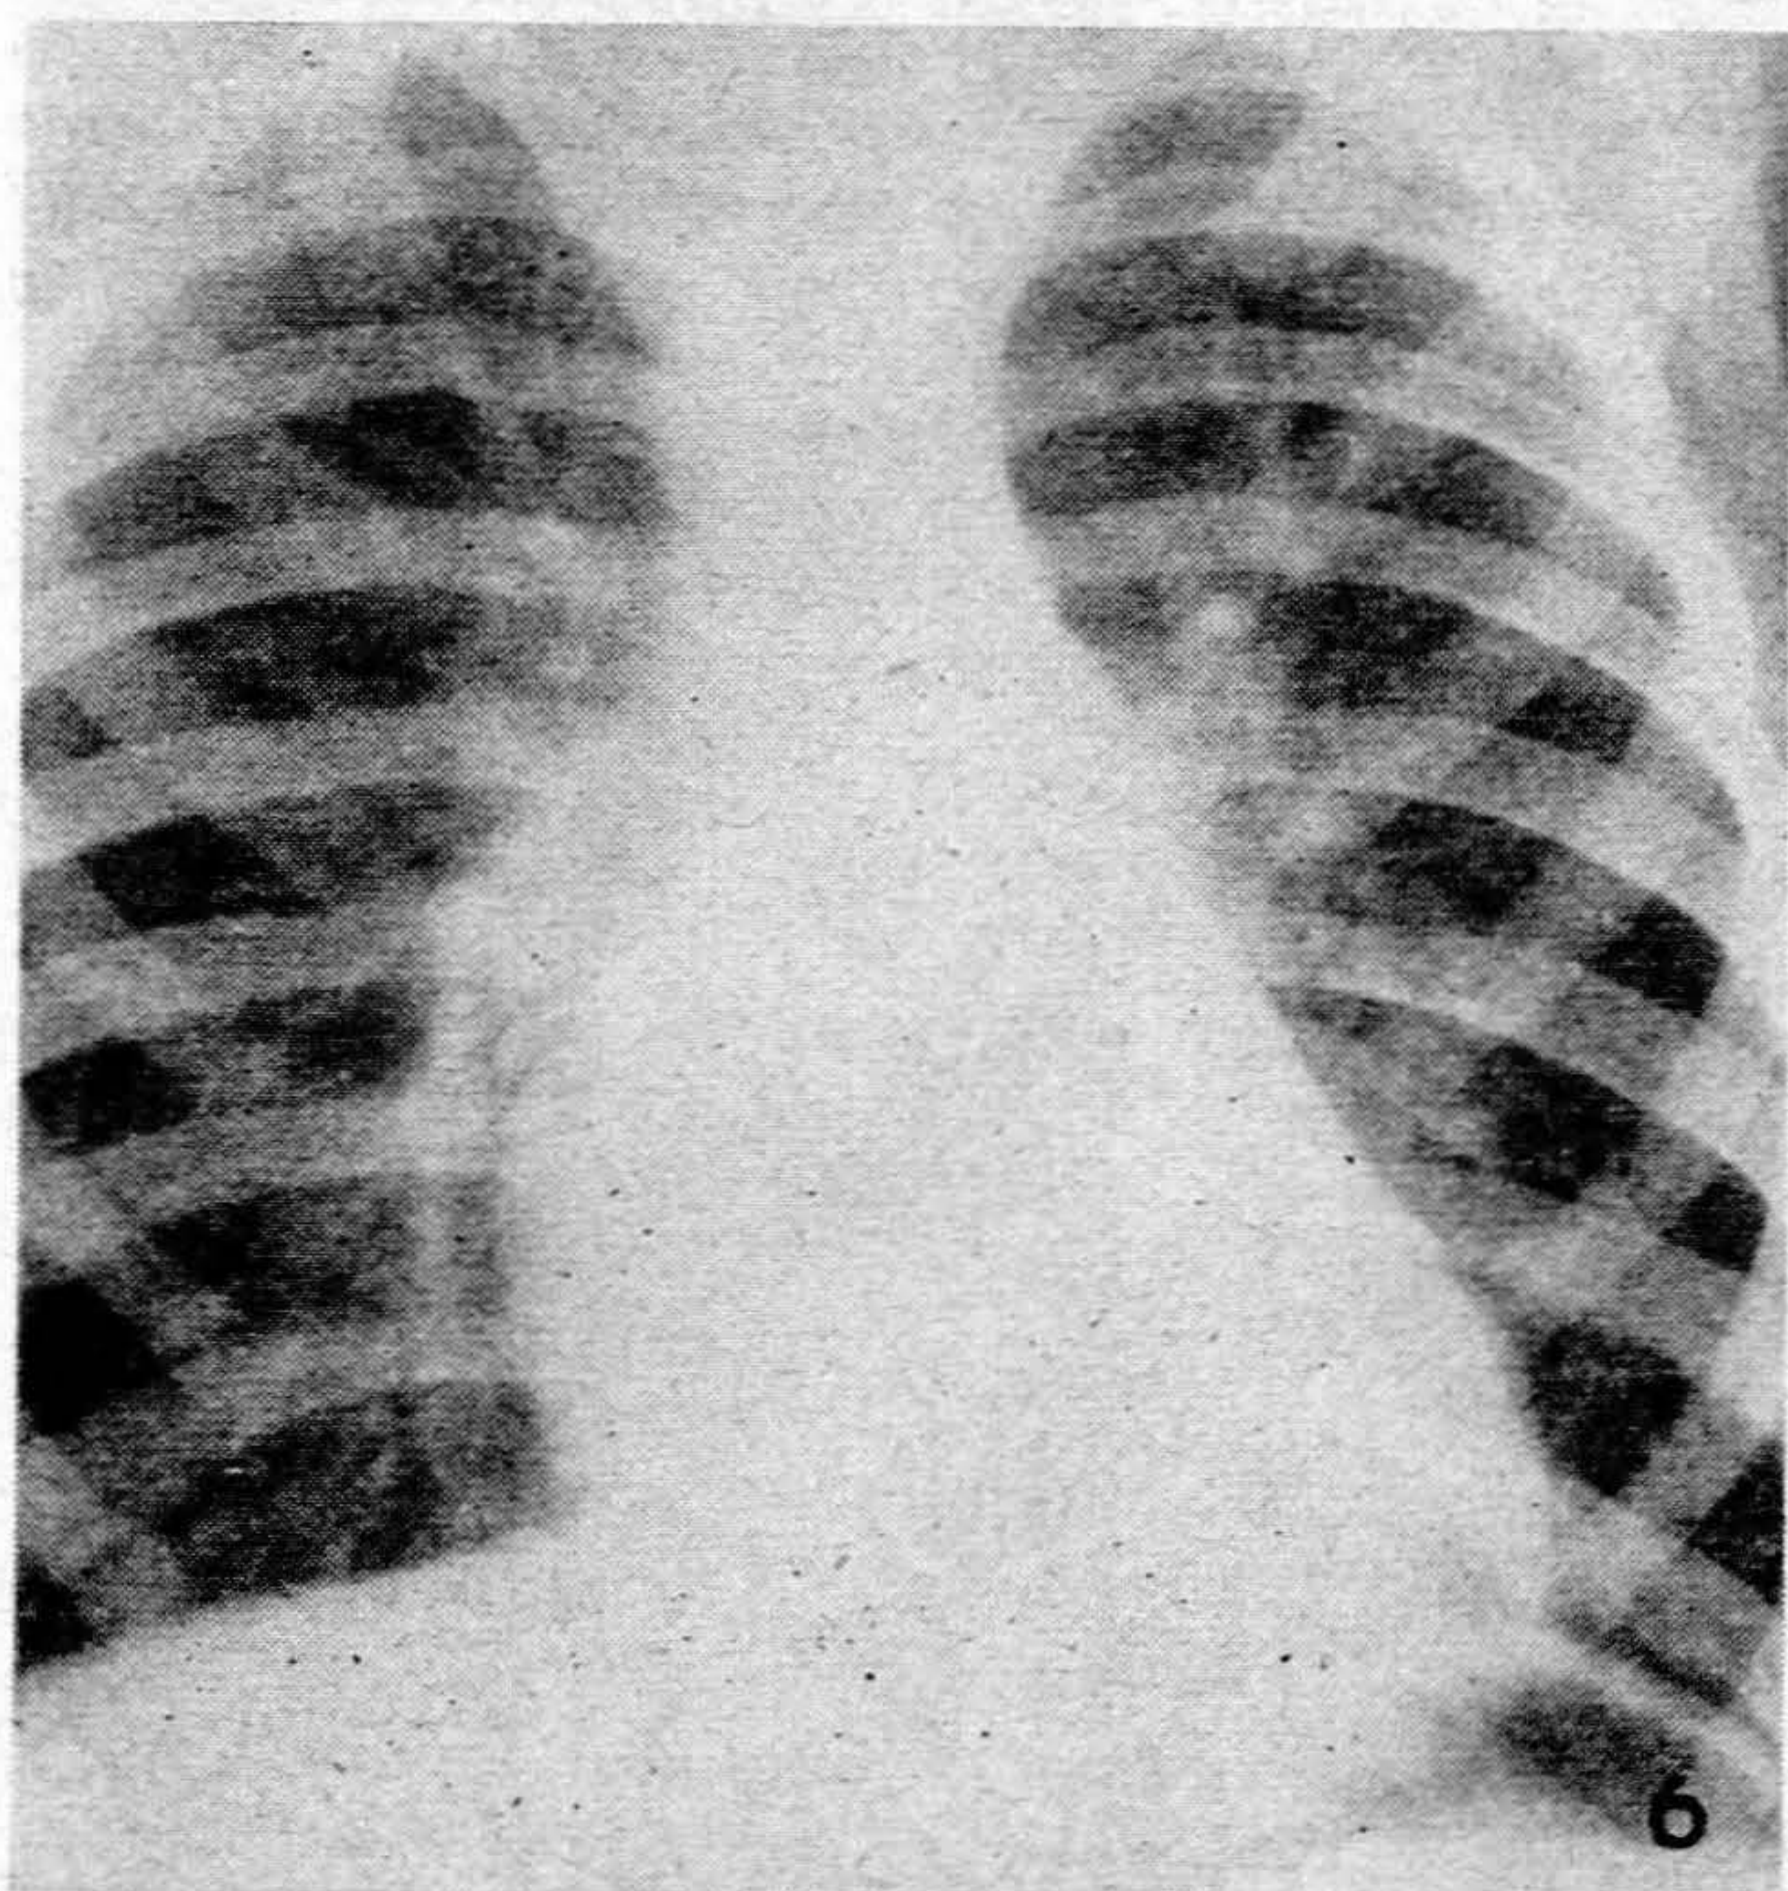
Radiograph showing right and left ventricular enlargement, prominent pulmonary artery and prominent lung vascularity.
